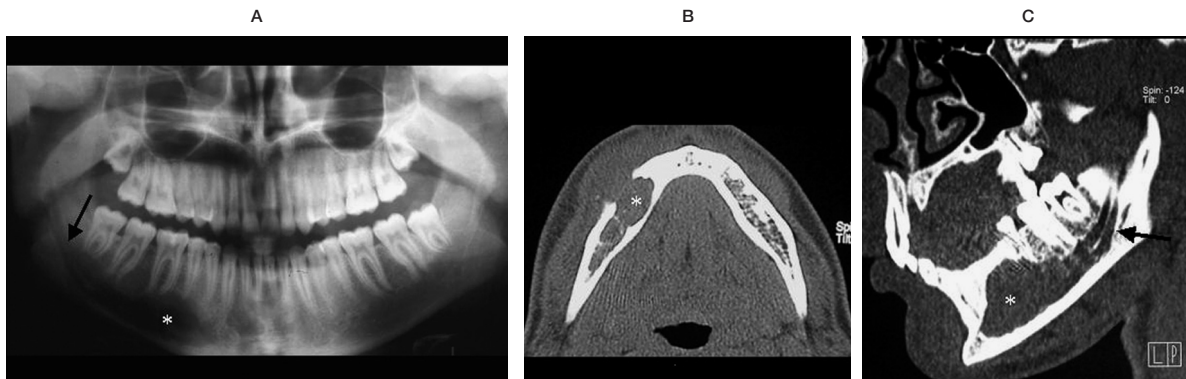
Panoramic radiograph (A), axial (B) and parasagittal (C) CT scan with bone algorithm. “Benign” lytic lesion in the right mandibular body (asterisk); double mandibular channel on the same side (arrow).
